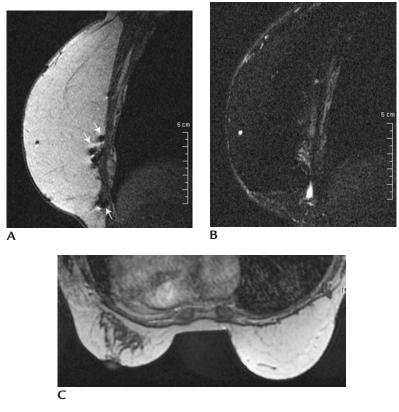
Right TRAM flap reconstruction with artifact from clips along chest wall. (A) Sagittal T1 weighted and (B) T2-weighted image (with fat suppression) of reconstruction site. "Bloom" artifact can be seen on the T1-weighted image along chest wall (*arrow*). (C) T1-weighted axial image demonstrating fatty tissue on the right.
